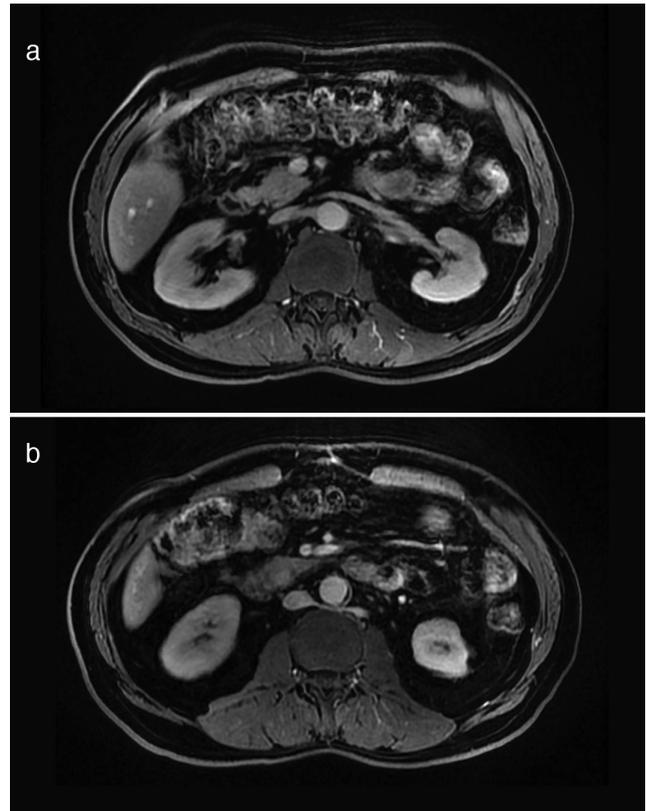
Axial plane MRI showing the circumaortic position of the left renal vein. The left renal vein reaches both the anterior (a) and posterior (b) of the abdominal aorta
